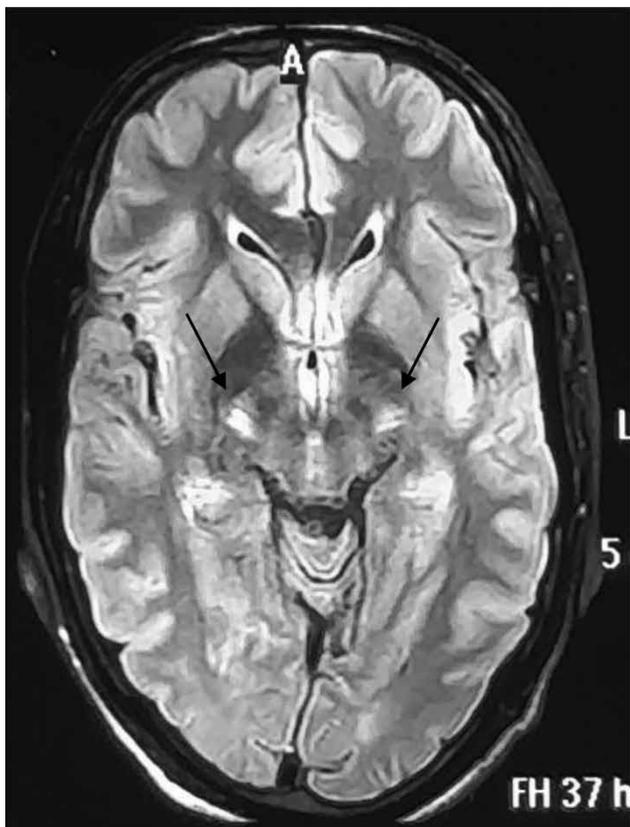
MRI brain axial section showing bilaterally symmetrical hyperintensities involving the corticospinal tracts in crus cerebri.
